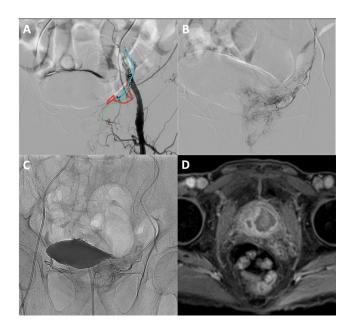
(A). The left external iliac arteriography shows collateral from the left inferior epigastric artery (*red line*) to the left prostatic artery (*green dots line*) via left obturator artery (*blue line*). (B). Selective imaging of the left prostatic artery through the collaterals. (C). Single shot image after bilateral prostatic artery embolization. (D). MRI at the 6-month follow-up showed significantly decreased prostatic volume with central necrosis zones.
